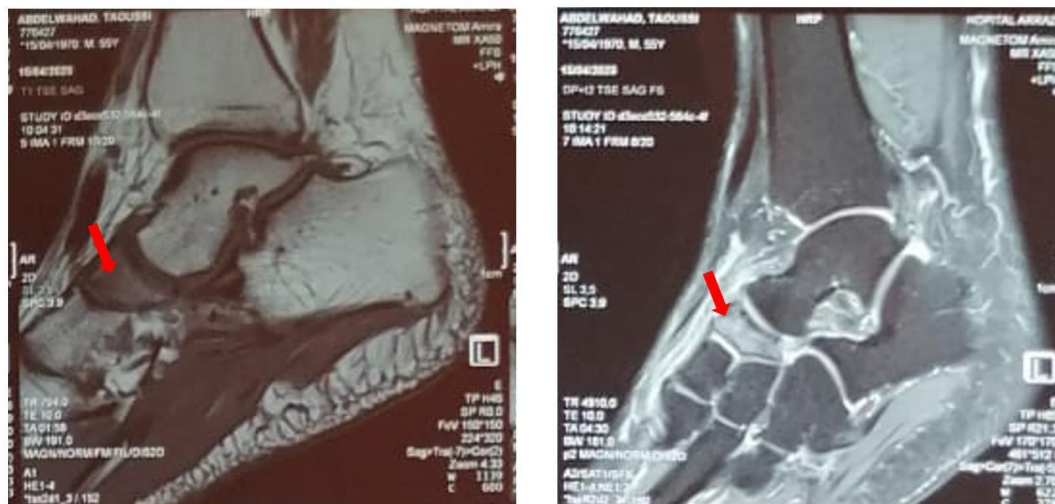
MRI of the right ankle in sagittal T1- and T2-weighted sections showing a flattened and deformed navicular bone and a patchy signal abnormality with low T1 signal and high T2STIR signal
